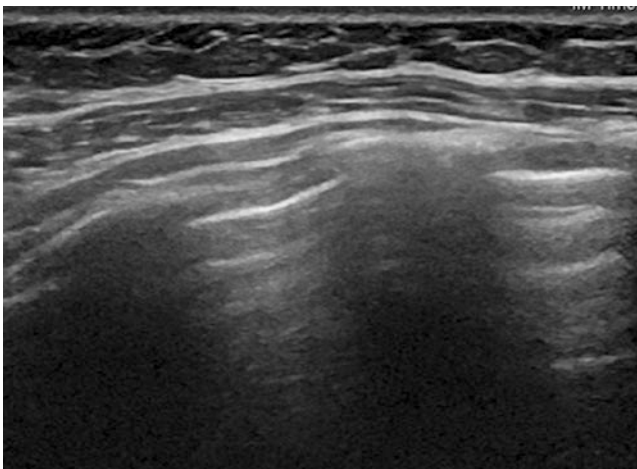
Ultrasound of normal lung parenchyma using a linear array transducer. Structures of the chest wall include the subcutaneous soft tissues, muscles, and rib shadows. Between the ribs are horizontal dense lines representing the pleural line. Parallel to pleural lines are multiple echogenic horizontal lines called as A-Lines, which are evenly spaced representing reverberation artifacts from the pleural lines in normal lung tissue
